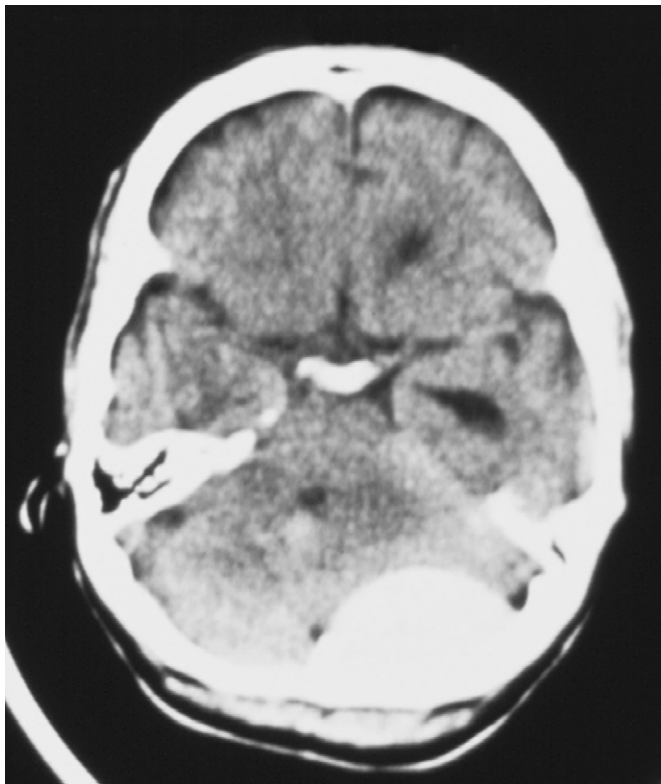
Non-contrast-enhanced computed tomography scan of large left posterior fossa, epidural hematoma. The size of the lesion at this high level suggests that it crosses into the supratentorial compartment. This lesion is often associated with occipital bone fracture that disrupts transverse sinus.
